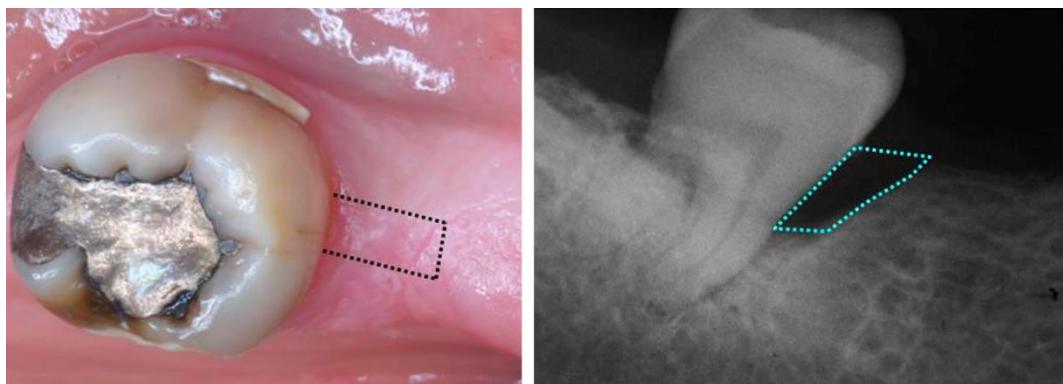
Representation of sample removal for an isolated tooth. Oclusal view with incision scheme and the radiographic image representing the depth of the incision.
